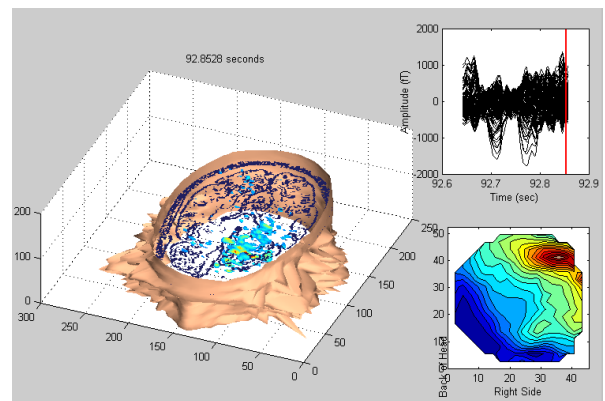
Near the end of a segment of MEG data prior to seizure, the primary epileptic focus is active in the 2DII source activity image. External distortion of the patient skull is due to artifacts in the MRI data used to generate the 3D surface. The data segment and the top view contour plot of the MEG data are included.
